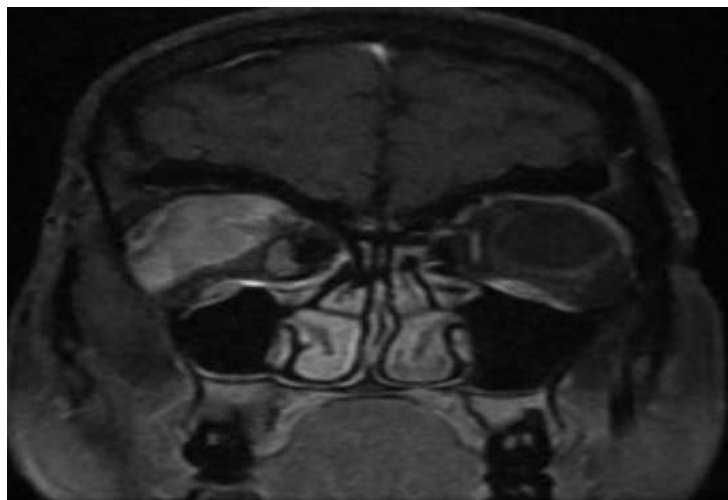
MRI of the orbit, frontal section showing the progression of the intra-orbital tissue process in comparison with the initial MRI.
